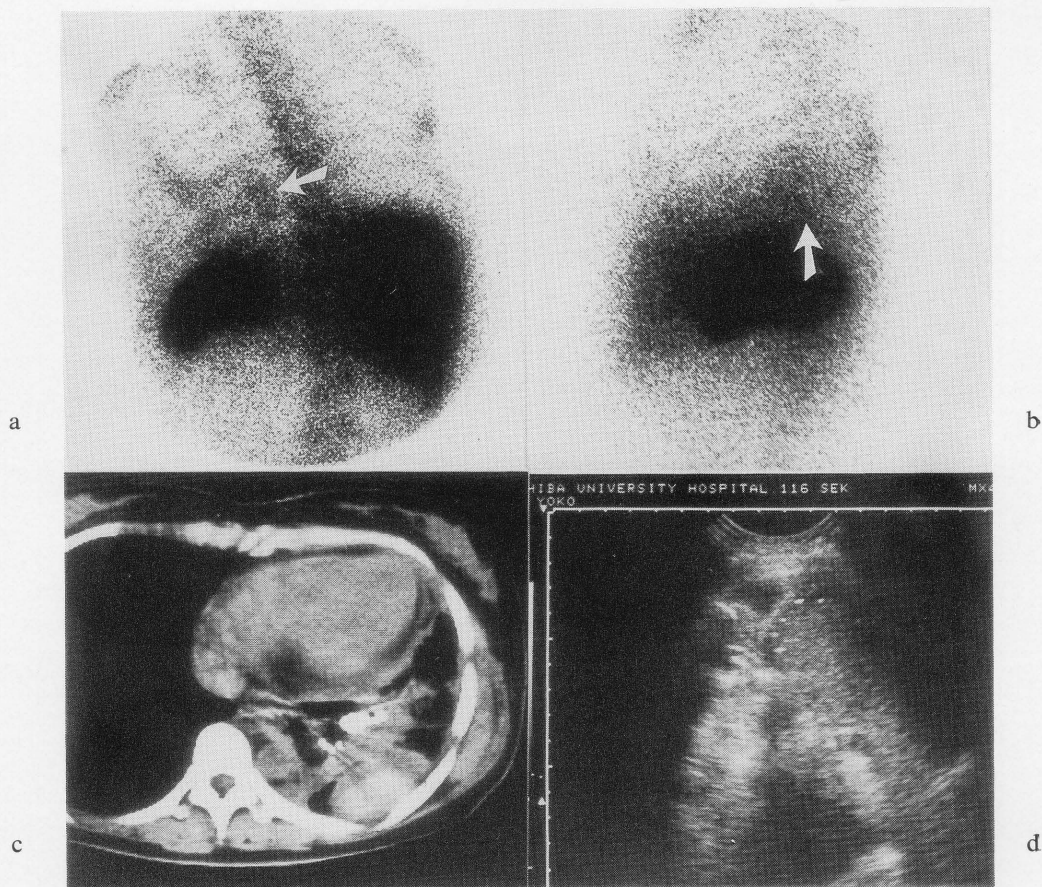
Case 2. Patient post-esophagogastrectomy with fever. In-111 WBC images (a. LPO view, b. left lateral view) show a spotty accumulation in the intrathoracic lesion (white arrow). A CT scan demonstrates an abscess (c) and an intercostal US scan demonstrates fluid collection (d).
